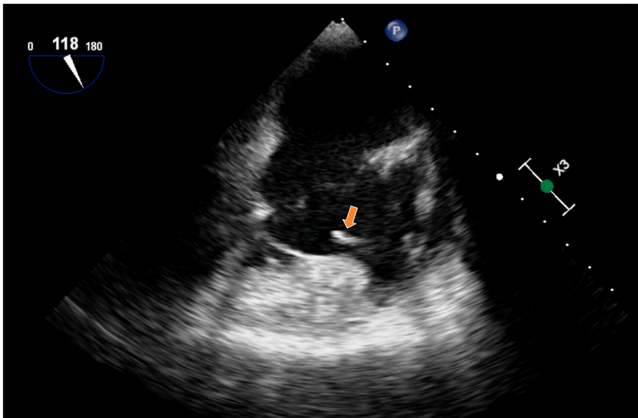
Vegetation on right ventricular pacemaker lead on transthoracic echocardiogram.
